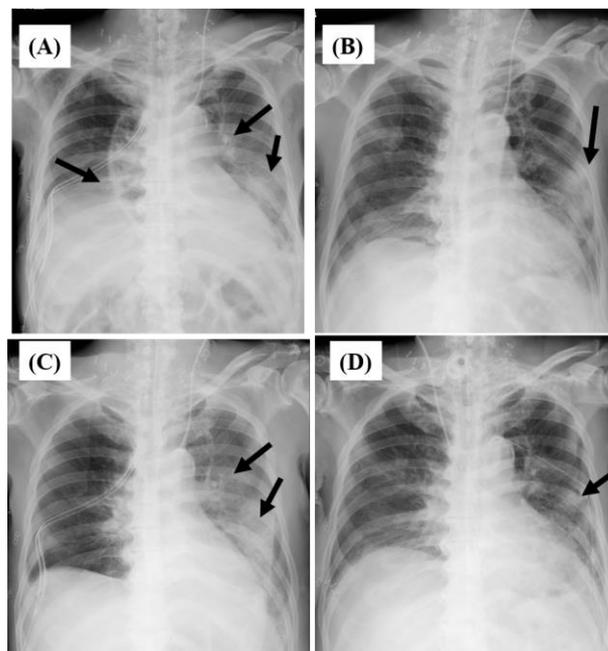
Chest X-rays of the case 1 patient. Infiltration shadow is seen in both lung fields on day 0 (A). The shadows are improved on piperacillin/tazobactam on day 10 (B). The shadows have worsened again on day 14 (C), but have almost disappeared on day 28 (D). Arrows indicate abnormal shadows on chest X-ray, such as infiltration shadows.
